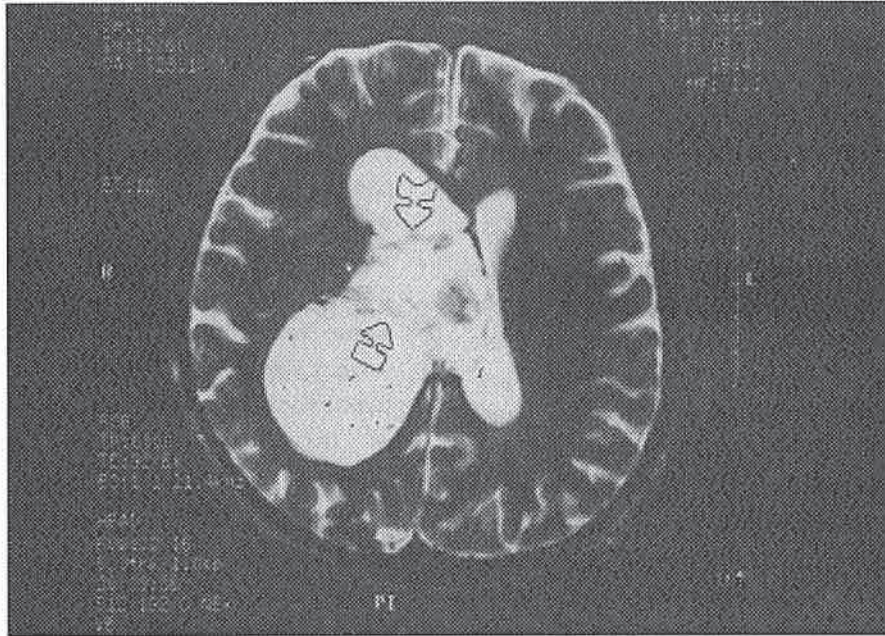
On the T2-weighted image, the cystic parts appear isointense with cerebrospinal fluid, and the solid parts are slightly hyperintense than gray matter. Note several hypointense septa rendering the lesion a multiloculated appearance (arrows)
